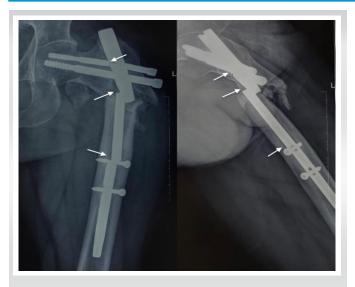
Pre-operative radiograph showing sites of implant failure (white arrows).
